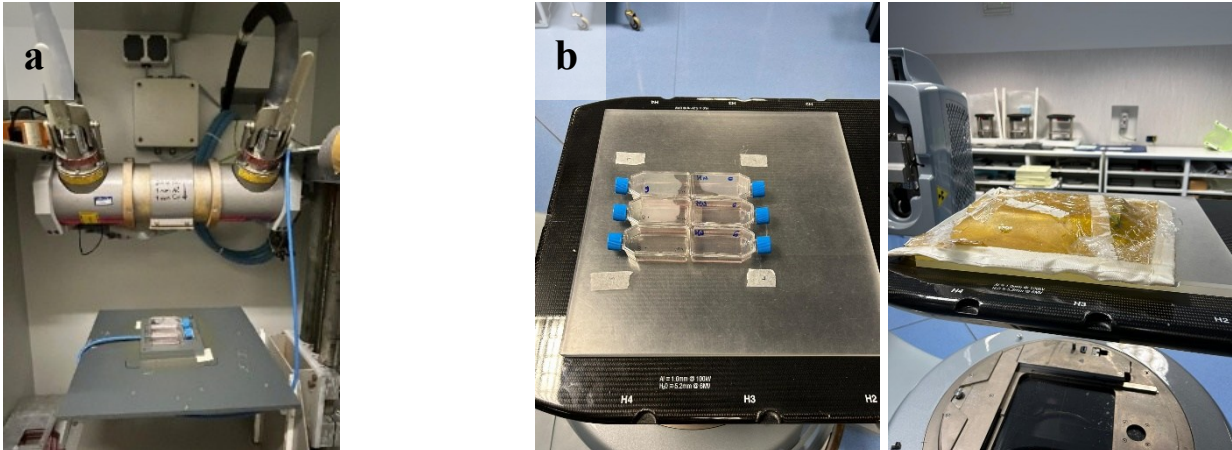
Experimental set up for X-ray irradiation at GSI (Darmstadt) and at Istituti Clinici Scientifici Maugeri (Pavia)
